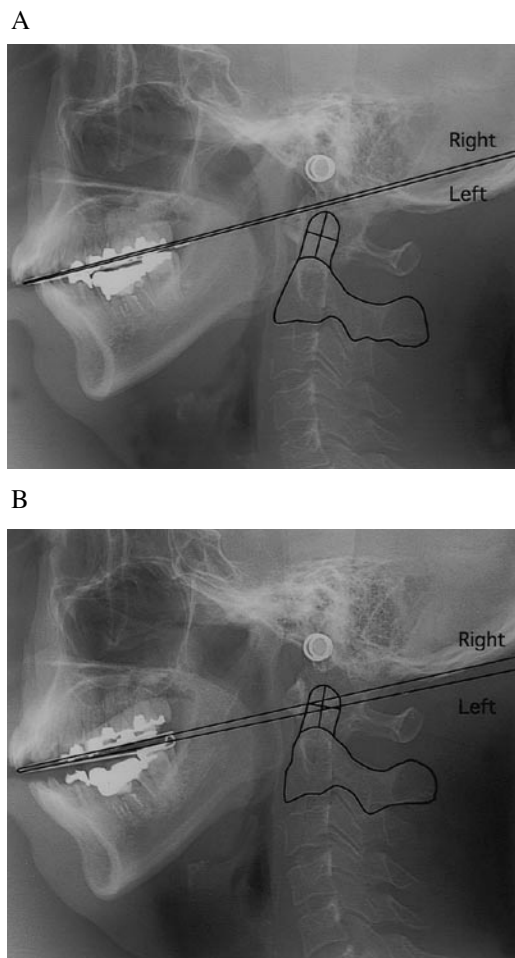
Representative lateral cephalometric x-ray profiles in a patient before and after dental adjustment treatment.
